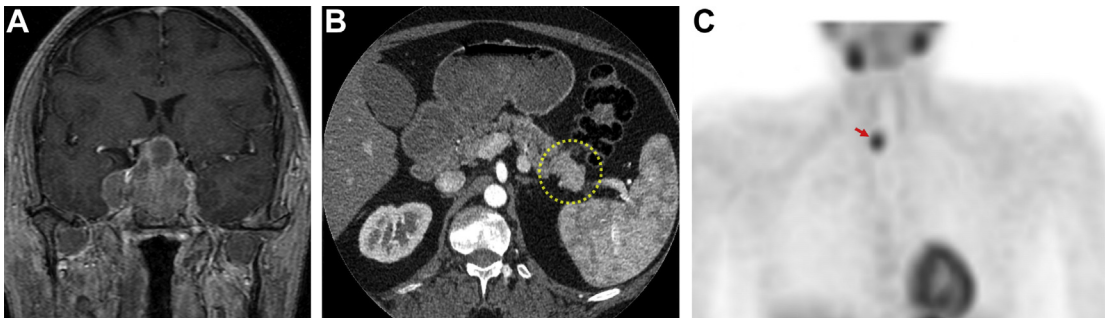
MEN1. (A) Coronal post-T1WI of the brain shows an invasive pituitary macroadenoma with right cavernous sinus invasion in a 40-year-old patient with MEN1. (B) Axial CT abdomen in the same patient shows a surgically proven neuroendocrine tumor in the tail of pancreas (*circle*). (C) Maximum intensity projection of a delayed (90 minute) ^{99m}Tc-sestamibi scan shows a right inferior parathyroid adenoma (*arrow*) in 49-year-old patient with MEN1.
